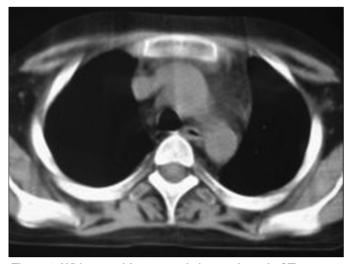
Widespread fat accumulation on thoracic CT
